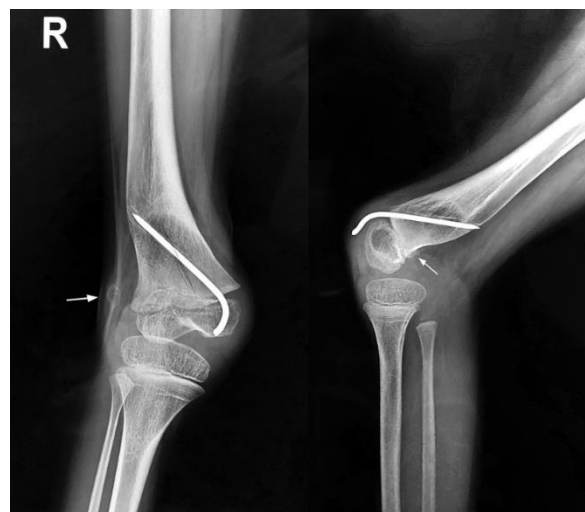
Anteroposterior (AP) and lateral radiographs of the right knee at the time the patient was referred for a second opinion. The first surgeon added a distal femoral varus component to the patient's deformity to improve the clinical knee valgus. Arrows point to the patella, which is now ossified and is visible along with a faint shadow of the patellar tendon.
